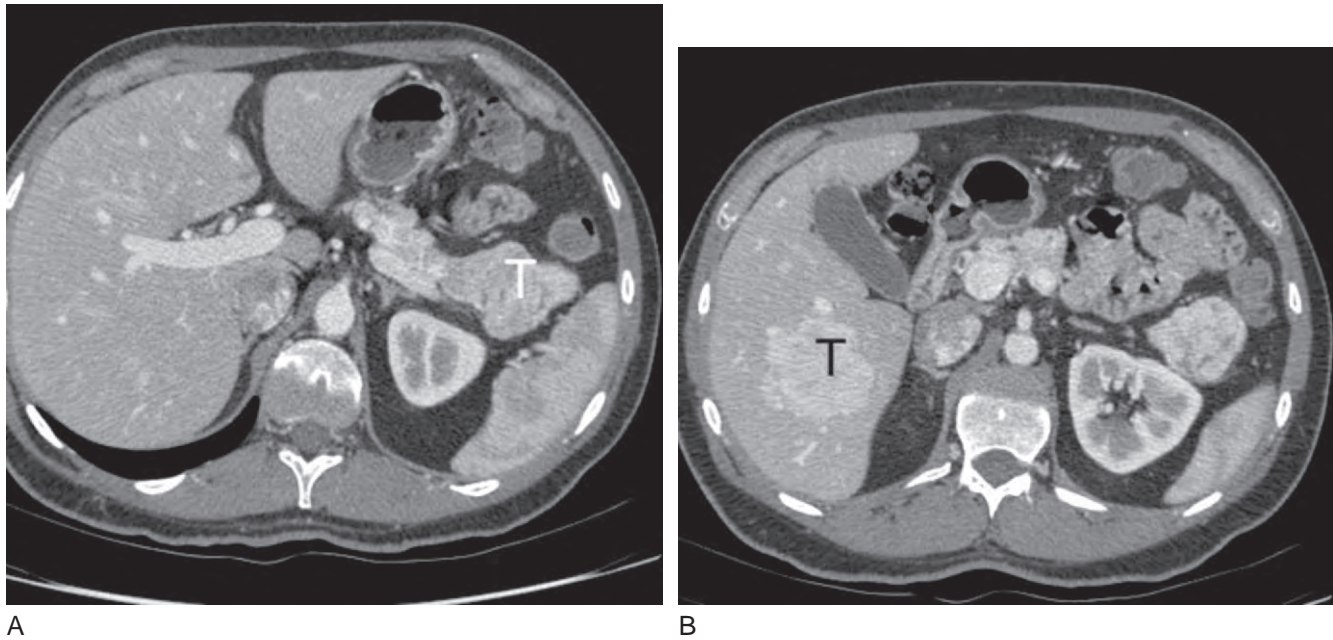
A, Glucagonoma (T) in the tail of the pancreas is demonstrated on CT scan. The patient presented with a rash known as necrolytic migratory erythema. B, The patient also had a large metastasis in the right lobe of the liver (T). He underwent a subtotal pancreatectomy/splenectomy and concomitant right hepatic lobectomy and recovered well. The rash resolved, and he has remained without imageable tumor for 2 years.
